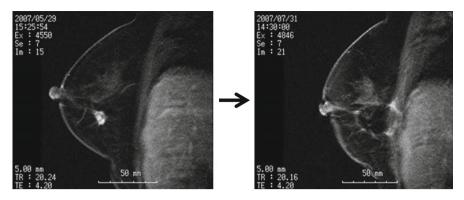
Enhanced MRI scans demonstrate successful RFA ablation. (a) An irregular, enhancing lesion is observed in the pre-RFA image. (b) After RFA, the tumour is no longer enhanced. A zone of ablation within the protein degenerative ring is demonstrated
